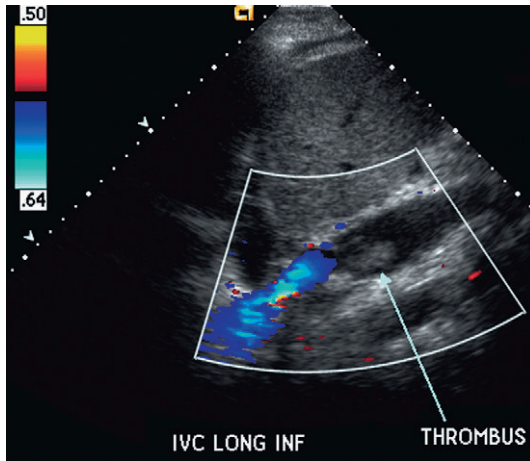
Longitudinal colour Doppler image of donor inferior vena cava. This liver is anastomosed with a piggyback technique therefore the flow within the cava is only a fraction of what it was previously. As a result clot has formed partially occluding the lumen (arrow).
